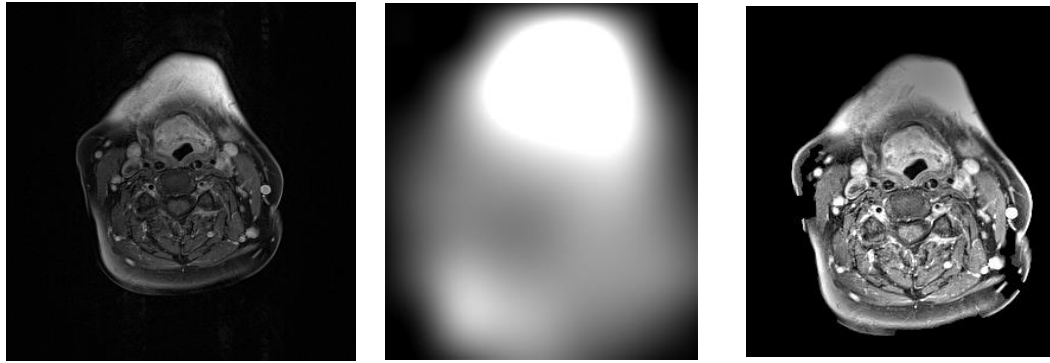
An example of bias field artefacts. (a) a HN MRI slice corrupted with bias field. (b) Estimated bias field in (a). (c) Uncorrupted (corrected) slice.
